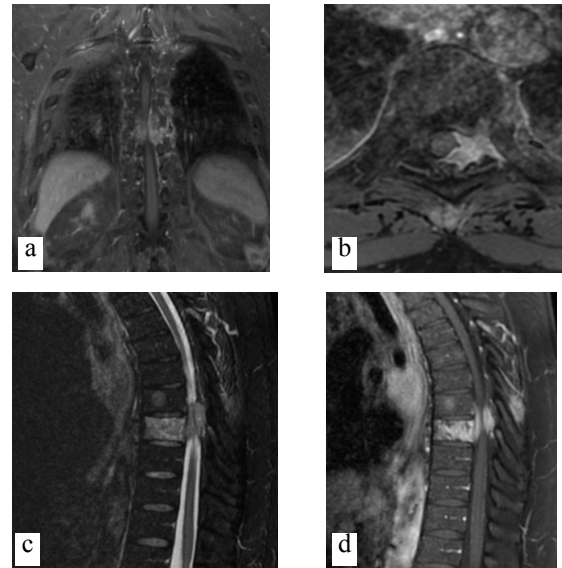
Magnetic resonance imaging (MRI): a and b coronal and axial T1-weighted images after gadolinium administration, showing a neoplastic involvement of T8 vertebral body. c T2-weighted images showing impingement of the spinal cord. d STIR sequence shows an osteolytic lesion on T8 vertebral body.
